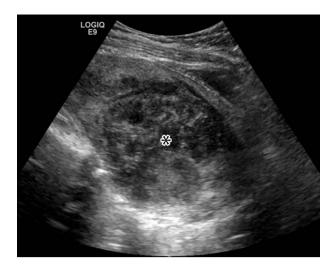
Transabdominal grayscale ultrasound image along the long axis of the uterus shows a large heterogeneous predominantly hypoechoic mass centered in the cervix extending into the lower uterine segment (*).
